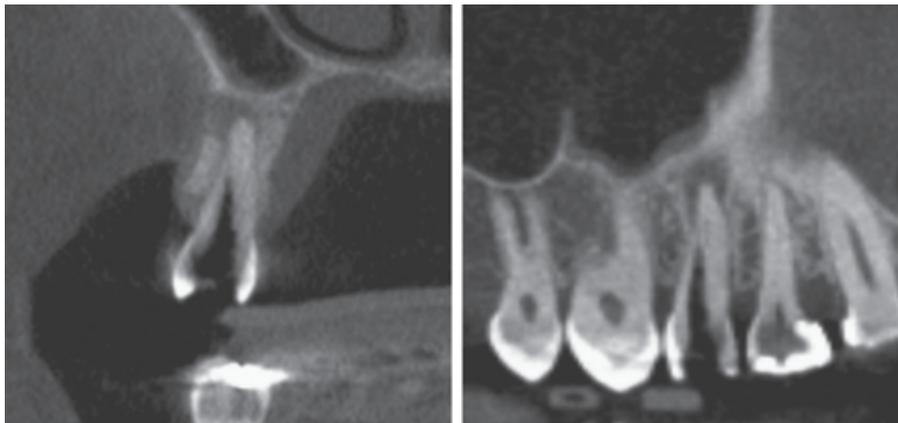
CBCT scan showing the deviation and perforation of the canal of the 15 (22).
